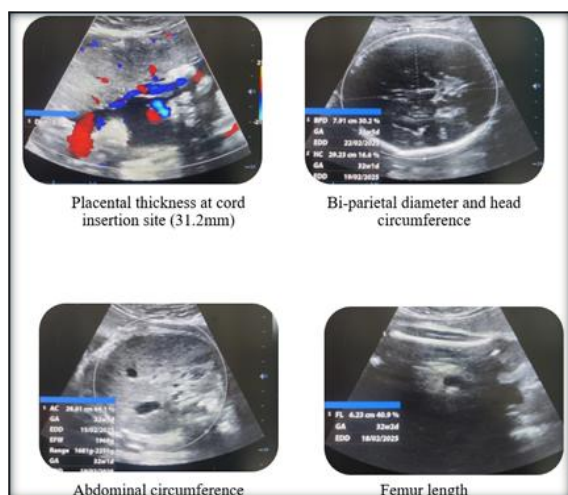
Case 1 showing Ultrasonographic Assessment of Placental Thickness and Fetal Biometry at 24 Weeks Gestation
